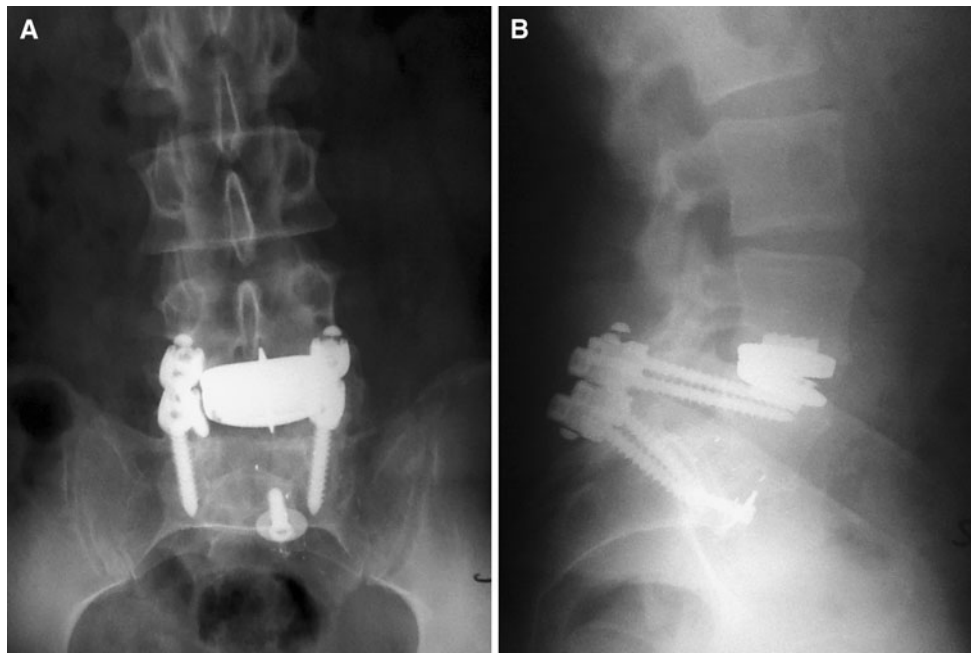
Pre-revision antero-posterior and lateral radiographs of a 50 year-old male patient, implanted with an artificial disc as a hybrid stabilization of L4–S1 (Case 5, Table 1), in which the original intent to treat the patient was nonfusion L4–L5 and fusion using PEEK rods
